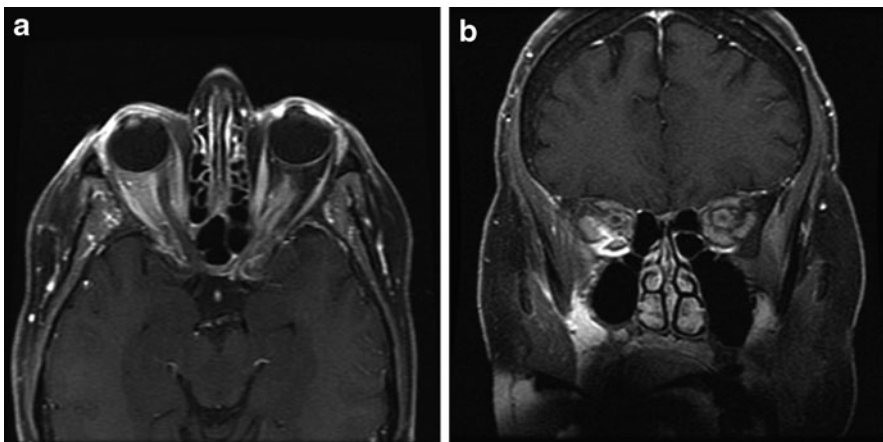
MRI meningioma OS (post-gadolinium): (a) axial, tram-track sign and (b) coronal, doughnut sign
